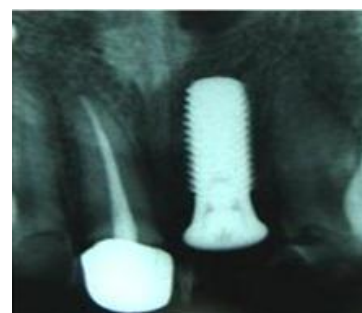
Radiograph showing immediate implant
